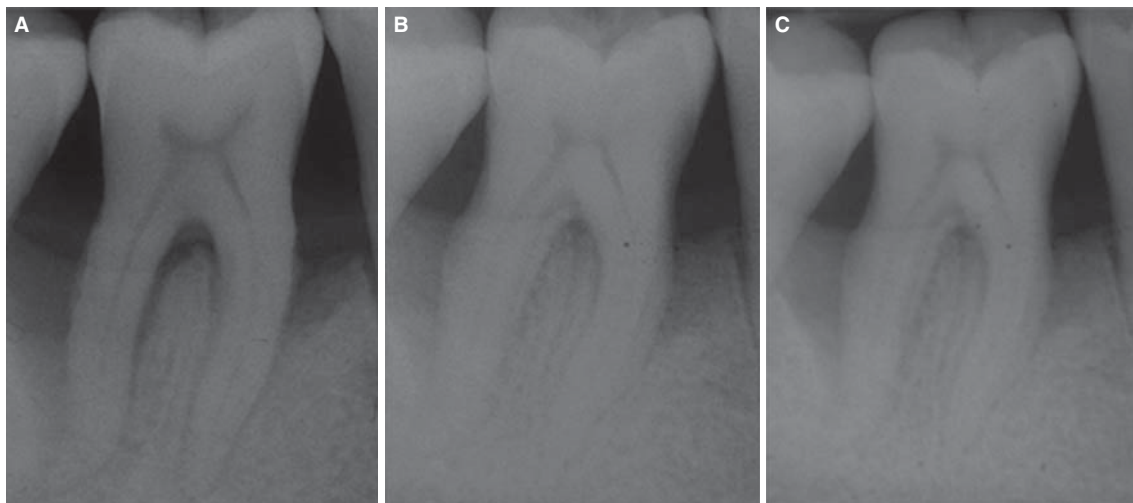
Radiographic appearances of osseous defect treated with PP/BM. (A) Baseline; (B) Post-operative 6-months; (C) Post-operative 5-years.
